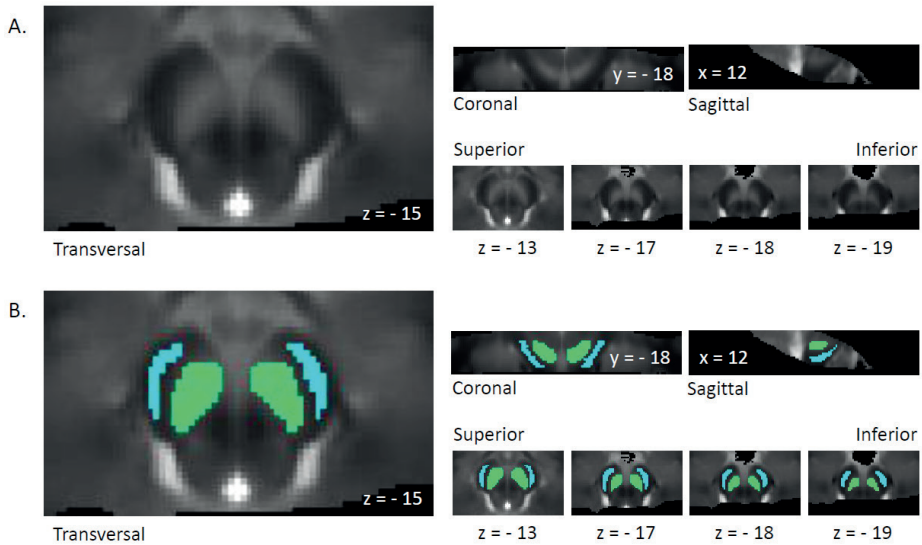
Template masks of the substantia nigra and the crus cerebri. A. Average image of spatially normalized NM-MRI images from 28 participants. The SN is visible as a hyperintense area. B. Template masks of the SN (in green) and CC (in blue) in MNI space were created by manually tracing the regions on the average NM-MRI image. The template masks were used for calculating the contrast-to-noise ratio in all subjects. Abbreviations: CC, crus cerebri; MNI, Montreal Neurological Imaging; NM-MRI, neuromelanin-sensitive magnetic resonance imaging; SN, substantia nigra.
